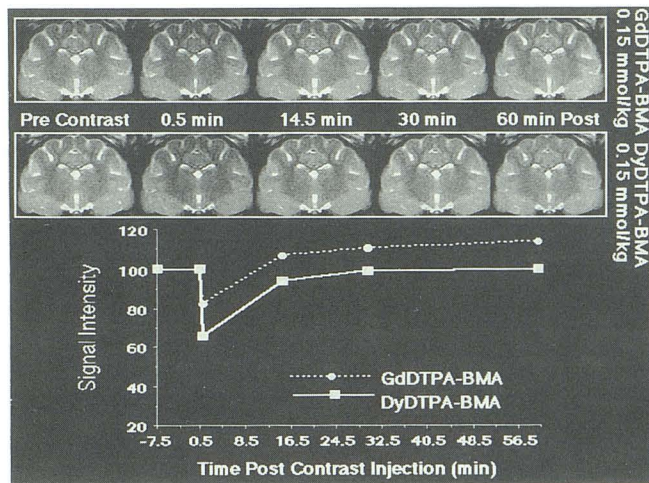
At 0.15 mmol/kg, DyDTPA-BMA injection induced a peak loss of signal intensity of 35%, whereas the same dose of GdDTPA-BMA produced an 18% reduction in T2-weighted image signal intensity compared with the precontrast image. GdDTPA-BMA administration was associated with a delayed persistent hyperintensity observed in the images acquired 32.5 and 56.5 min after contrast injection.
